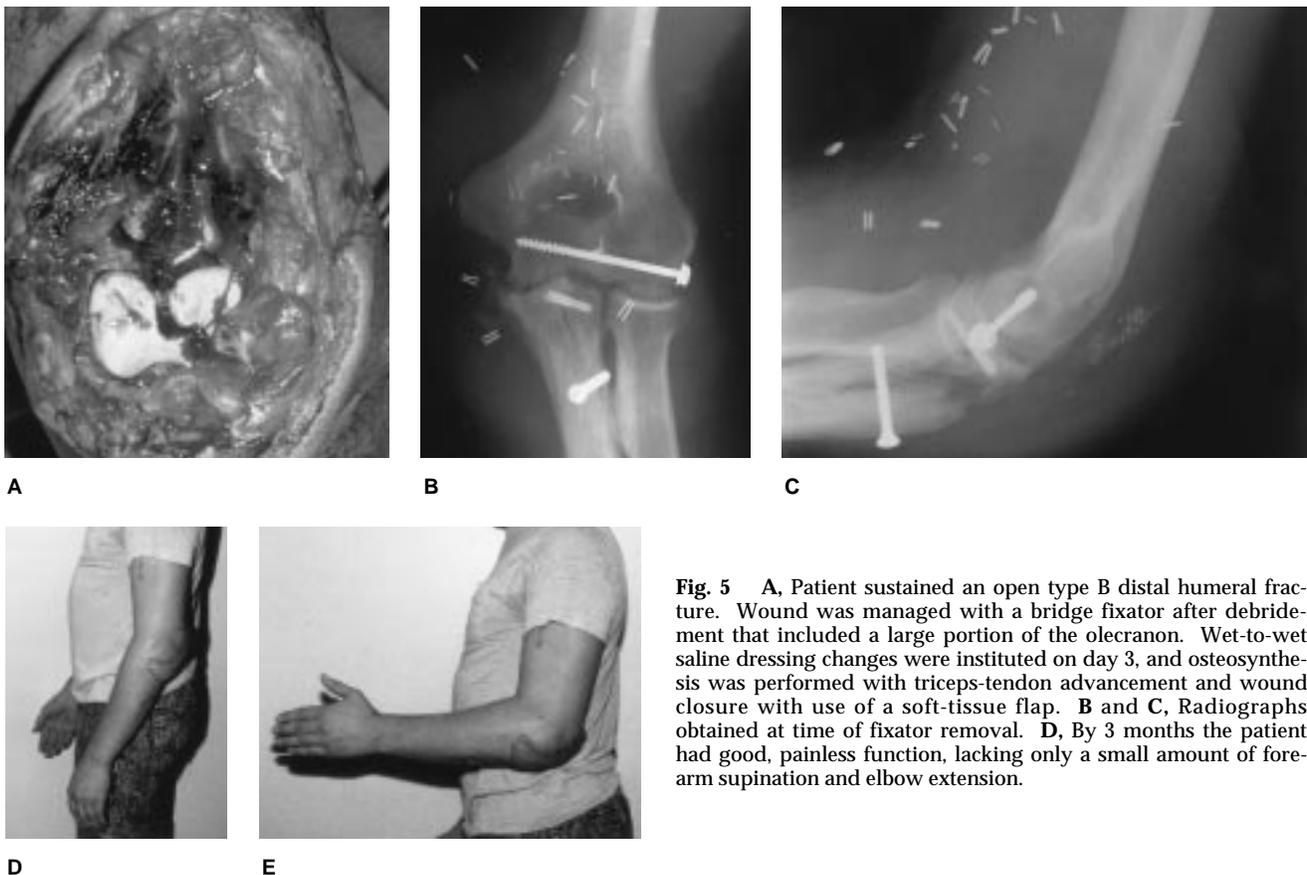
A, Patient sustained an open type B distal humeral fracture. Wound was managed with a bridge fixator after debridement that included a large portion of the olecranon. Wet-to-wet saline dressing changes were instituted on day 3, and osteosynthesis was performed with triceps-tendon advancement and wound closure with use of a soft-tissue flap. B and C, Radiographs obtained at time of fixator removal. D, By 3 months the patient had good, painless function, lacking only a small amount of forearm supination and elbow extension.
